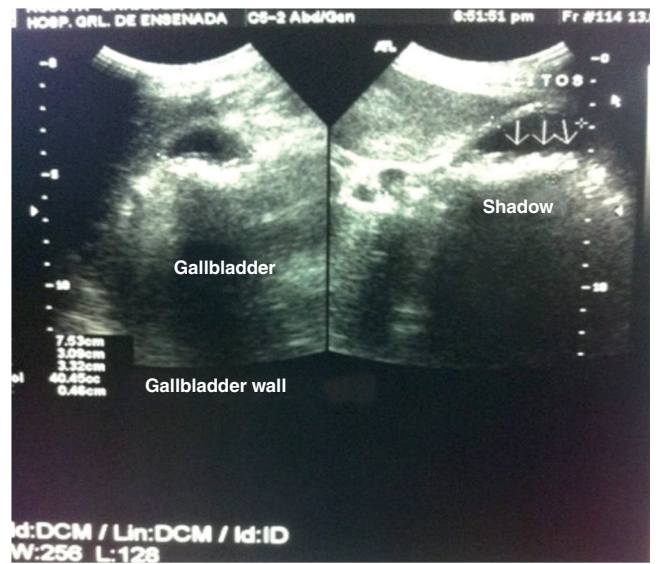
Gallbladder ultrasound where gallstones are visualized.
